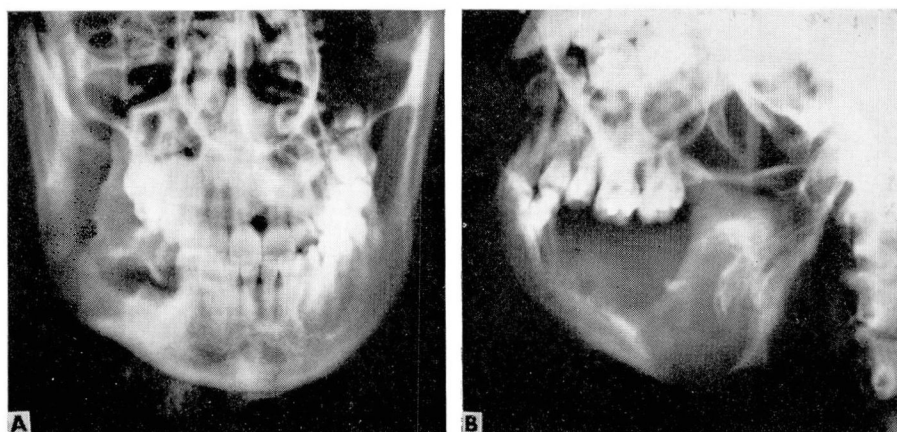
A and B, postoperative roentgenograms showing that removal of the tumor was complete, with the remaining buccal strut preserving the continuity of the mandible.
